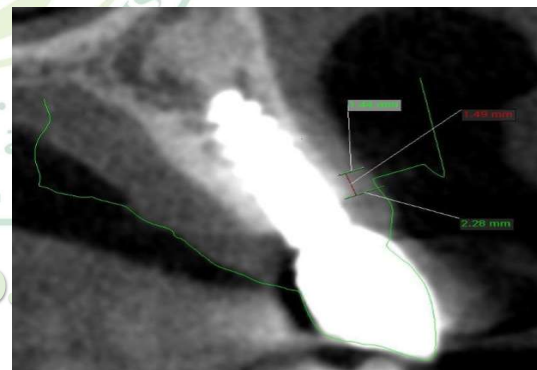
Cross-sectional cut showing registration of STL file on CBCT using OnDemand software.
